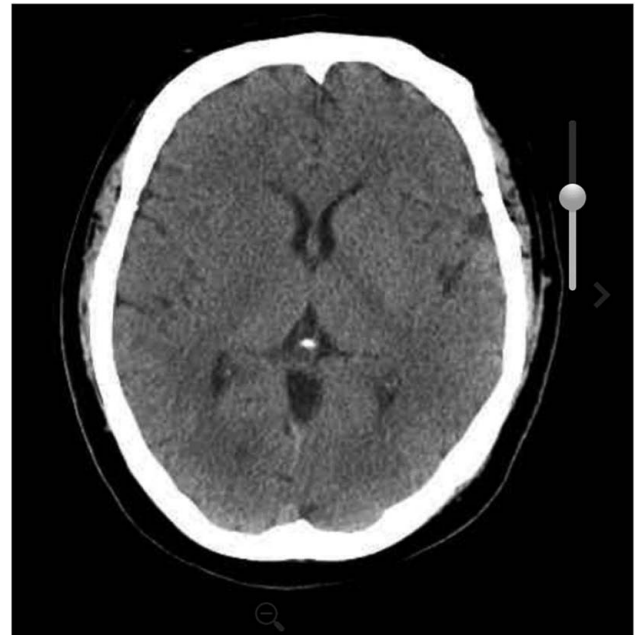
Computed tomography head (without contrast), maturation of acute infarction in the right basal ganglia.
